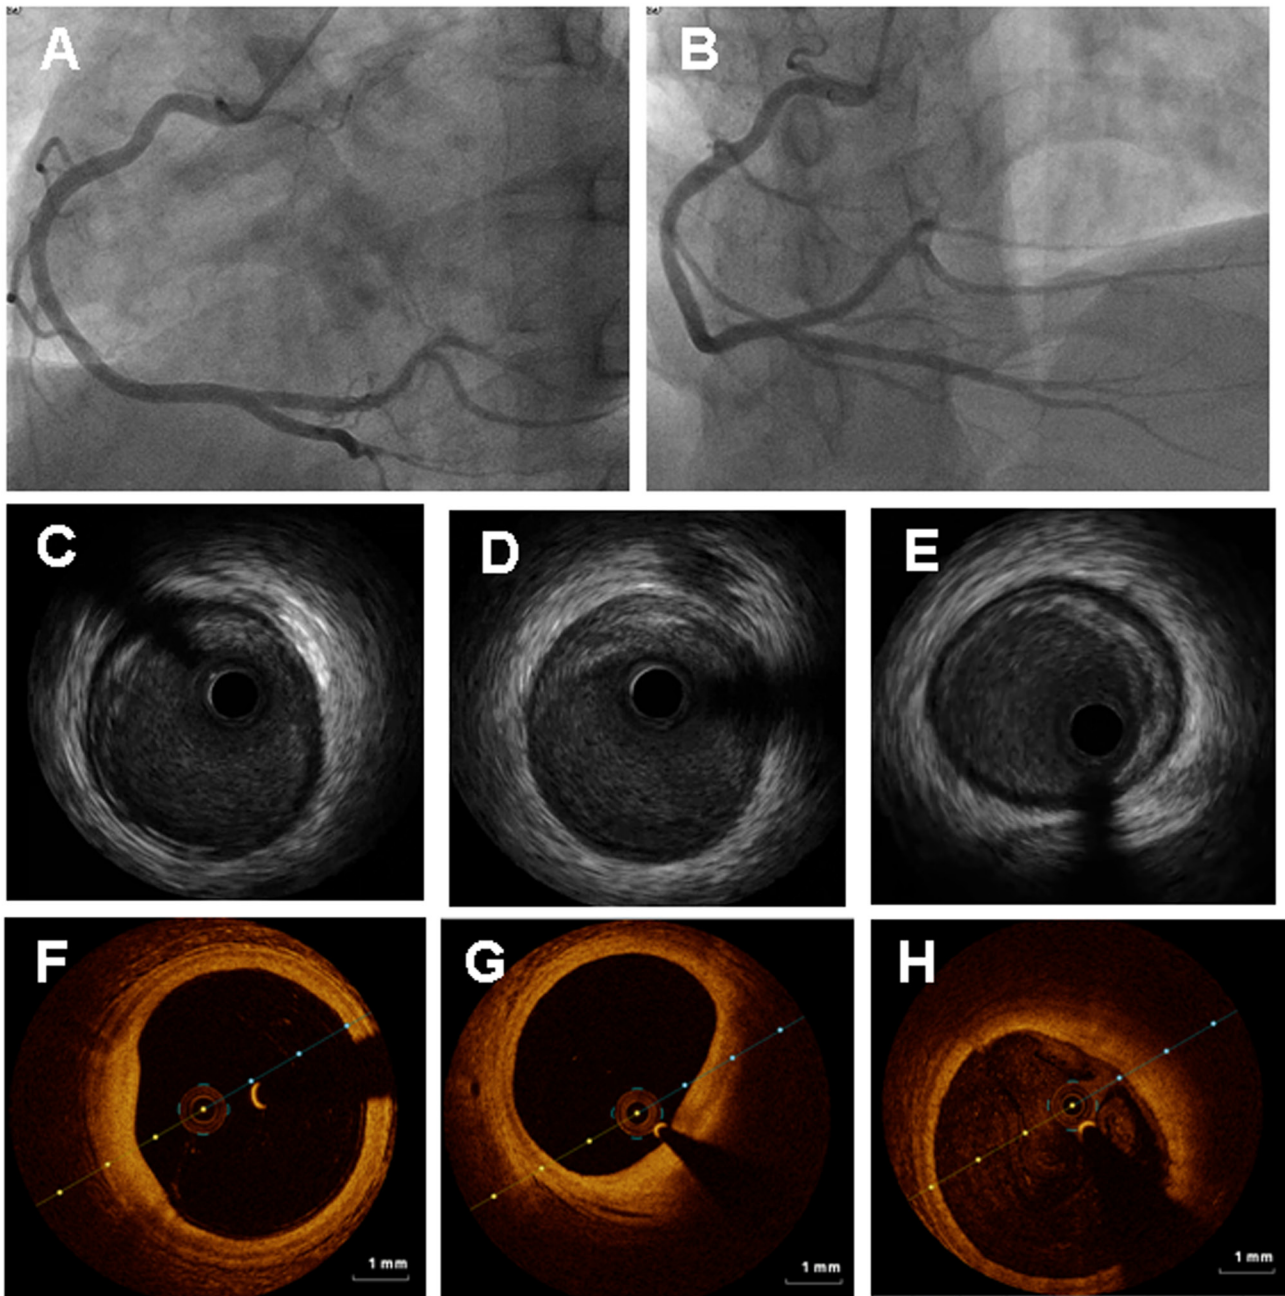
Results of the repeated coronary angiogram. (A) Coronary angiogram (left anterior oblique view) showed no dissection in the RCA. (B) Coronary angiogram (anteroposterior view) showed no dissection in the RCA. Intravascular ultrasound showed an isolated atherosclerotic lesion without arterial dissection in the RCA with the (C) proximal entry of SCAD, (D) middle of SCAD and (E) distal outlet of SCAD. Optical coherence tomography showed an isolated atherosclerotic lesion without arterial dissection in the RCA with the (F) proximal entry of SCAD, (G) middle of SCAD and (H) distal outlet of SCAD. RCA, right coronary artery; SCAD, spontaneous coronary artery dissection.
